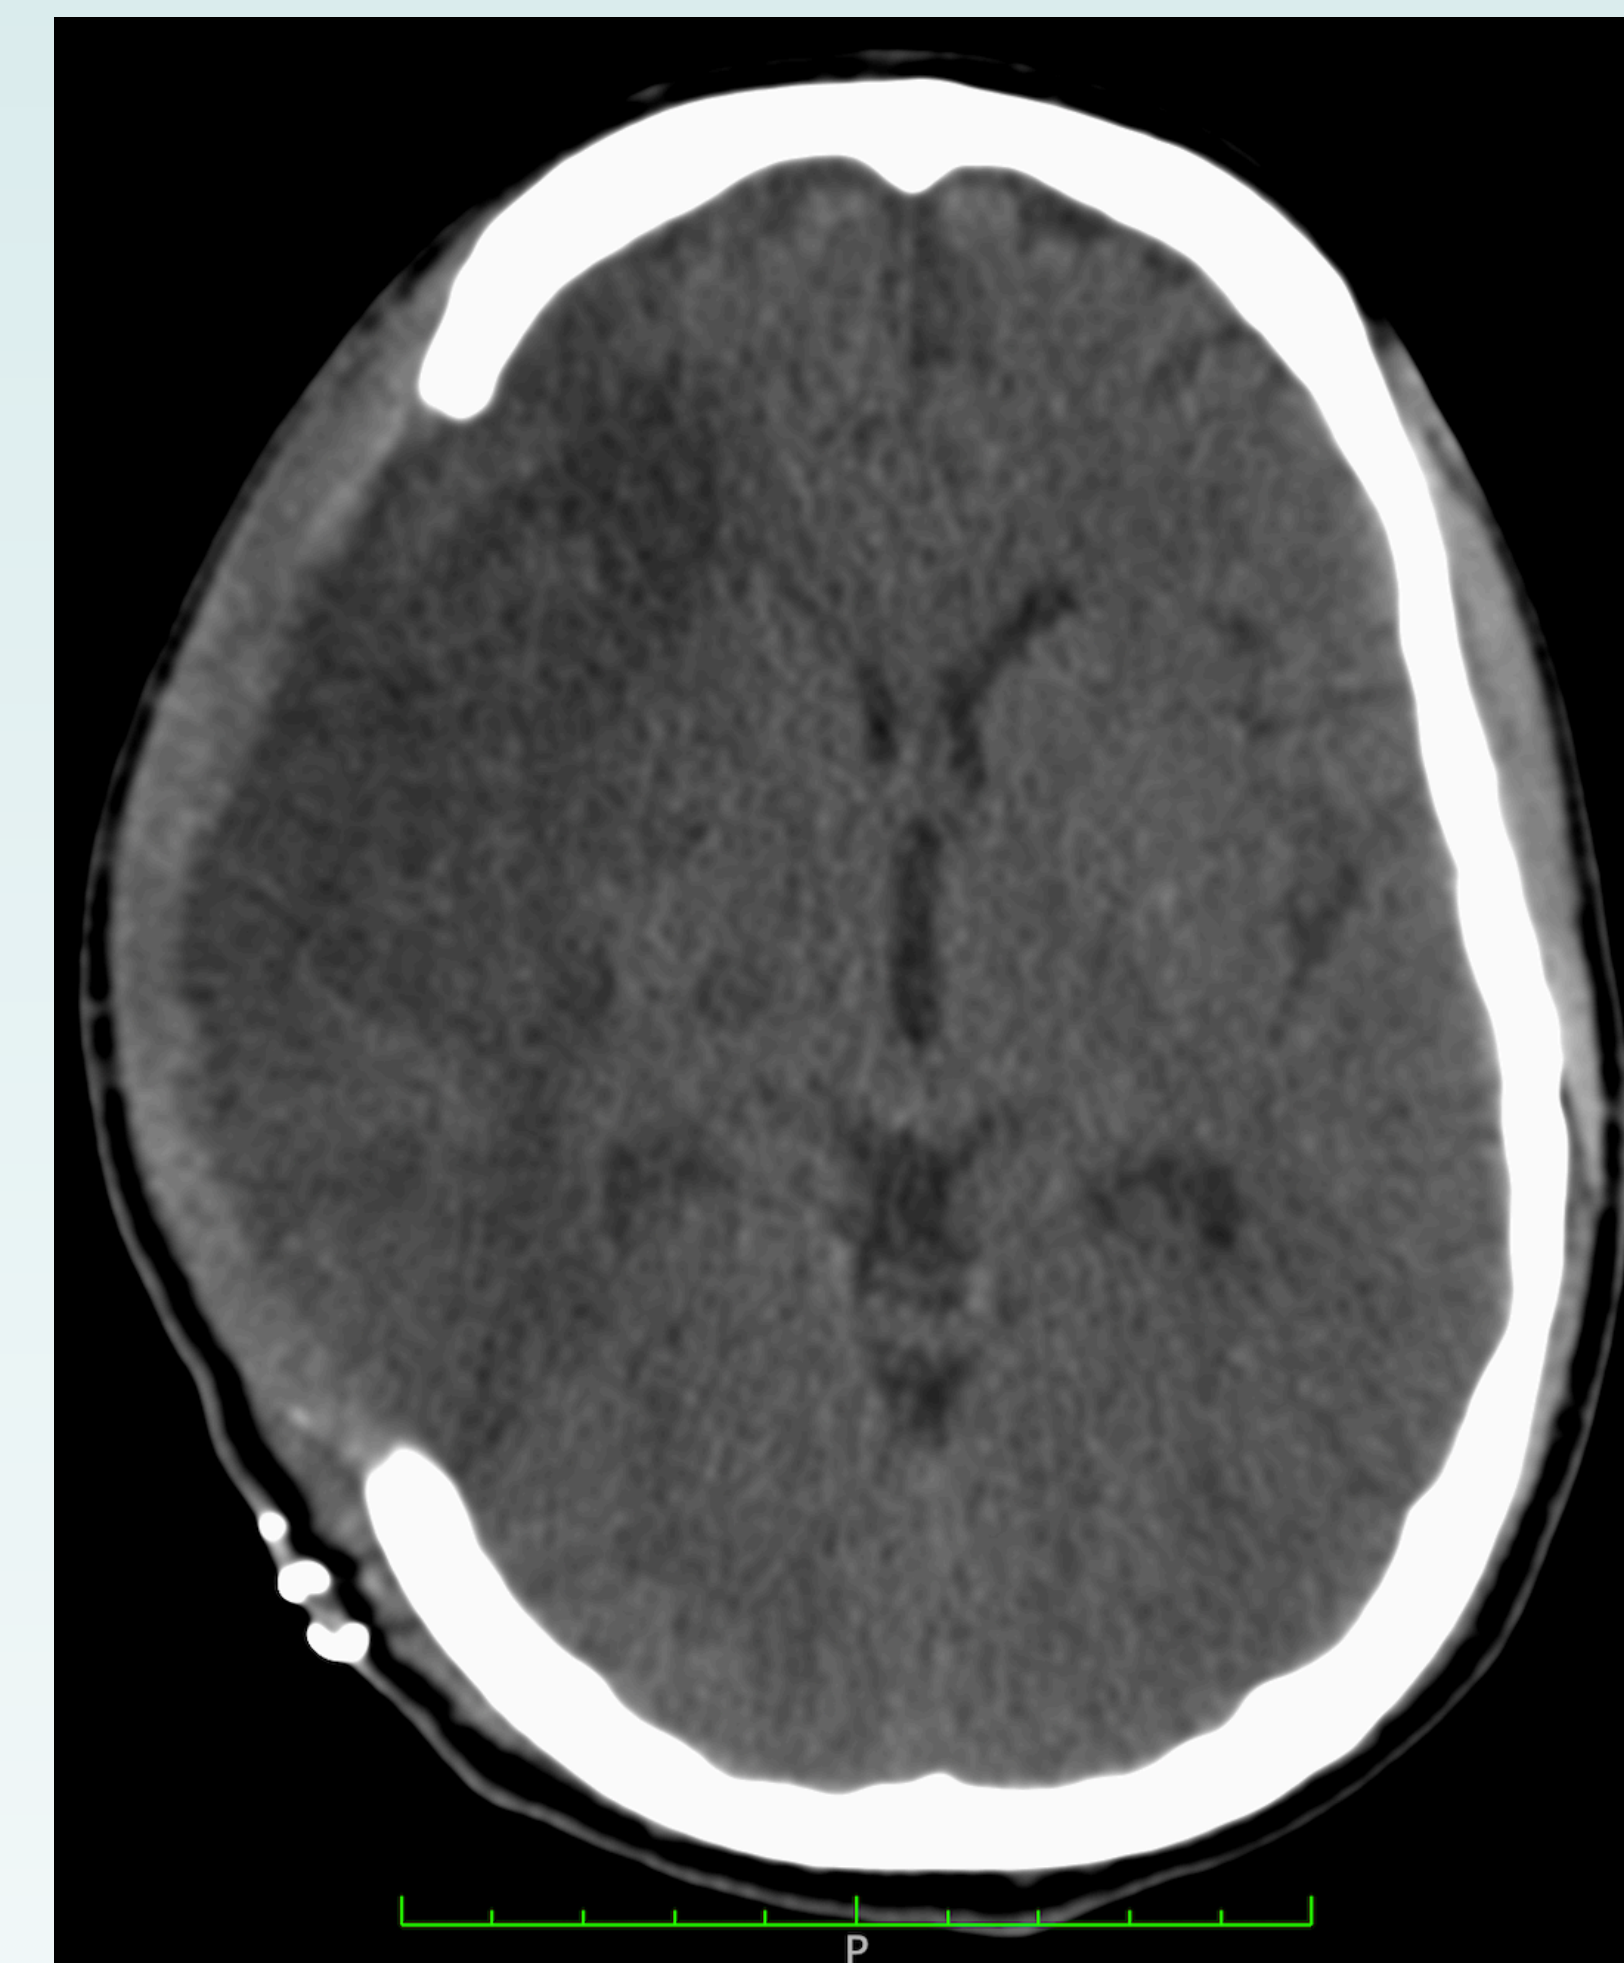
CT post-decompressive hemicraniectomy
